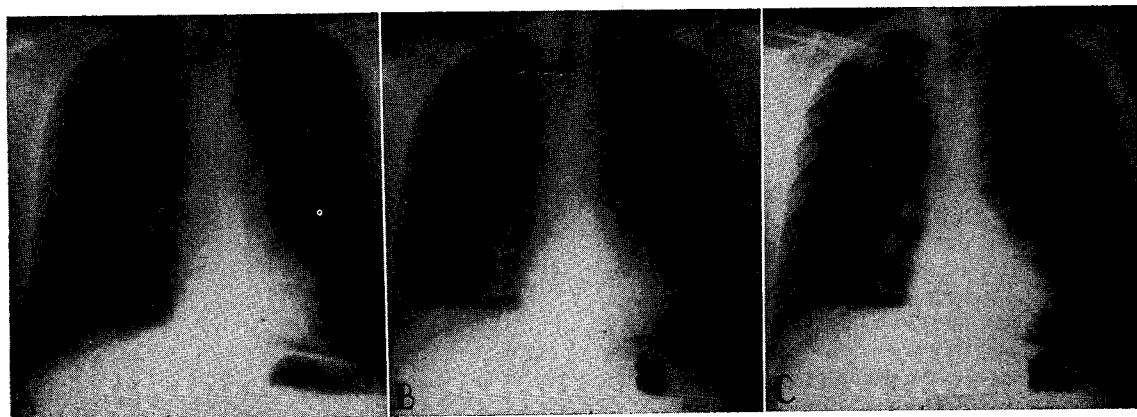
A, Chest roentgenogram before operation (September 18, 1961) showing prominent pulmonary arterial shadows, avascularity of the upper lobe of the left lung and tenting of the right hemidiaphragm. B and C, chest roentgenograms after operation (January 9 and April 8, 1962) showing decrease in size of pulmonary arterial shadows.
